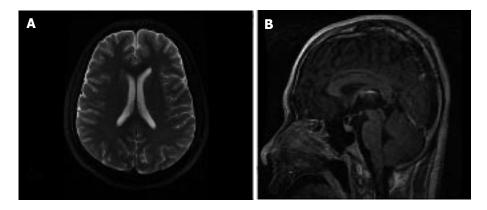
Transverse (A) and sagittal (B) views of magnetic resonance imaging was normal on admission.
